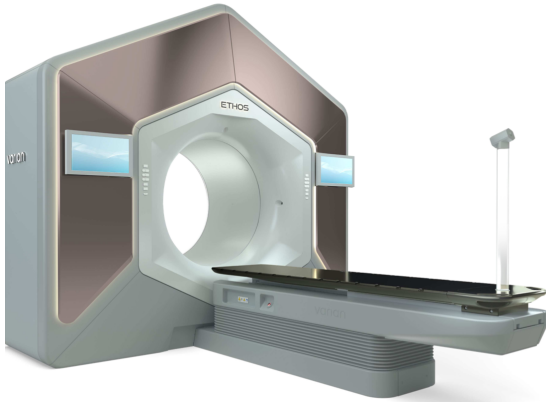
Ethos linear accelerator with a closed bore design and implemented AI system introduced in 2019 enabling a novel CBCT-based approach to oART [14].*
